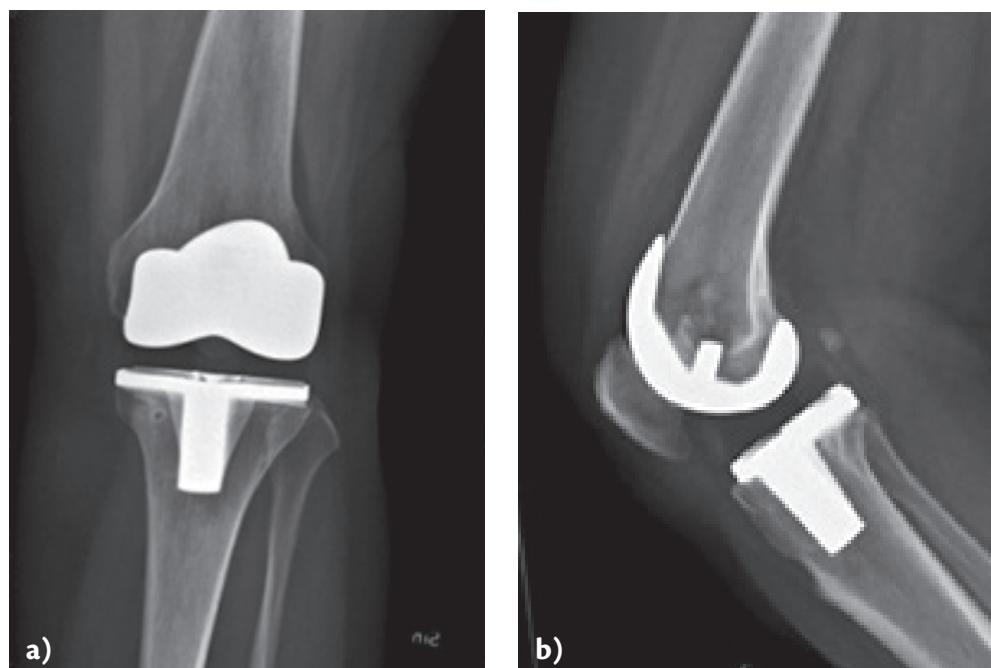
Total knee replacement. a) X-ray, front view; b) X-ray, side view.
